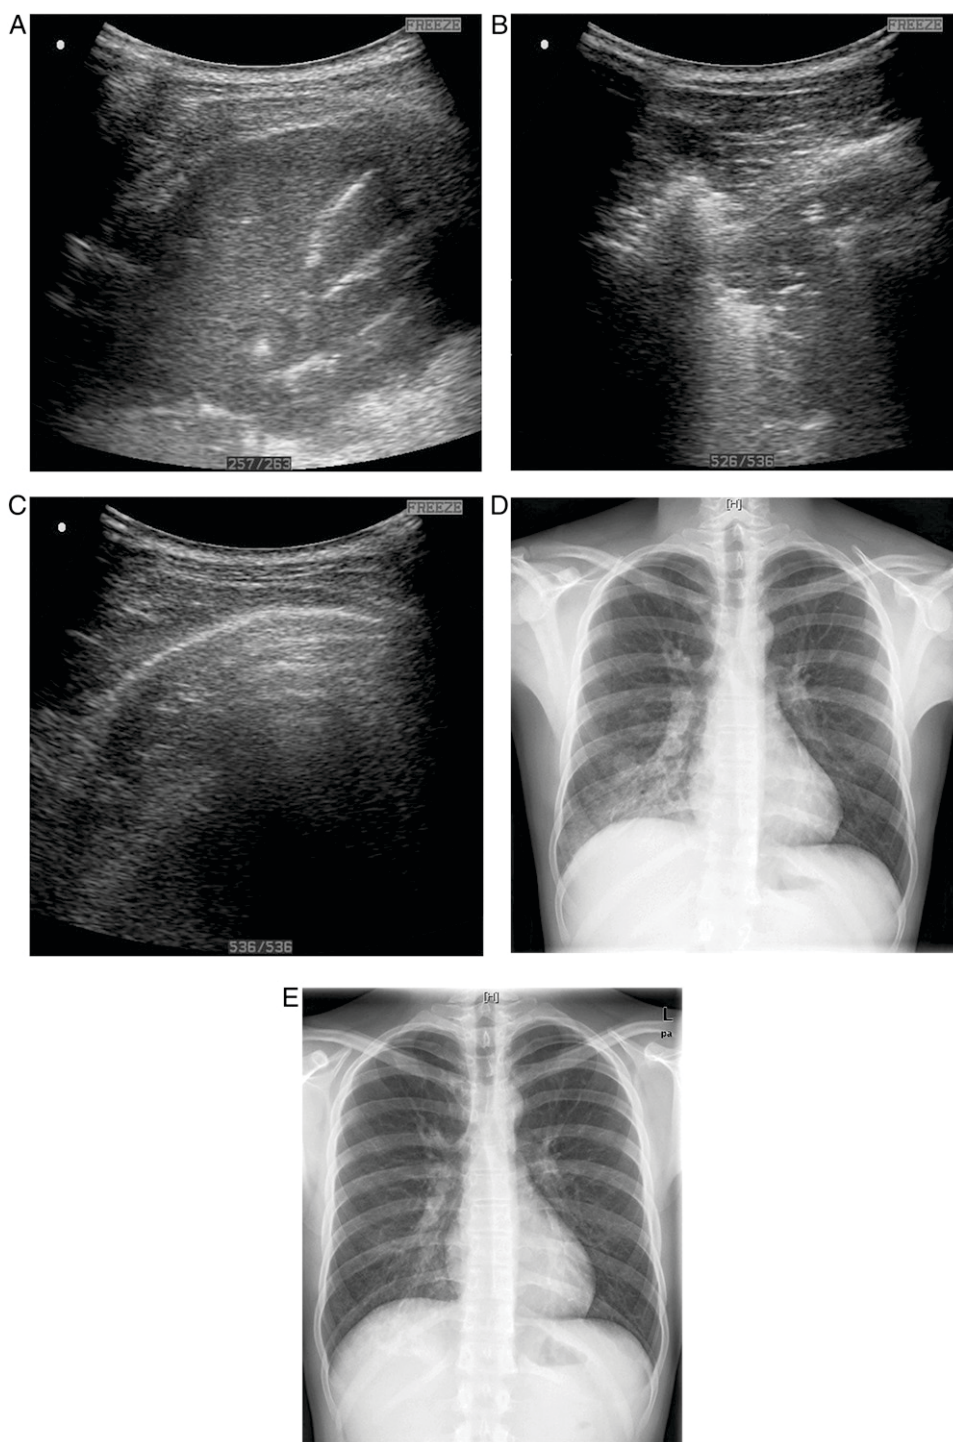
Patient with pneumonia caused by *Mycoplasma pneumoniae*. A, Positive air bronchogram reflecting pneumonia on day 0. B, Positive air bronchogram reflecting pneumonia on day 6. C, LUS showing no lesion on day 15. D, Radiograph showing infiltration in the right lower lobe on day 0. E, Radiograph showing postpneumonic residua on day 15. See Figure 1 legend for expansion of abbreviation.
